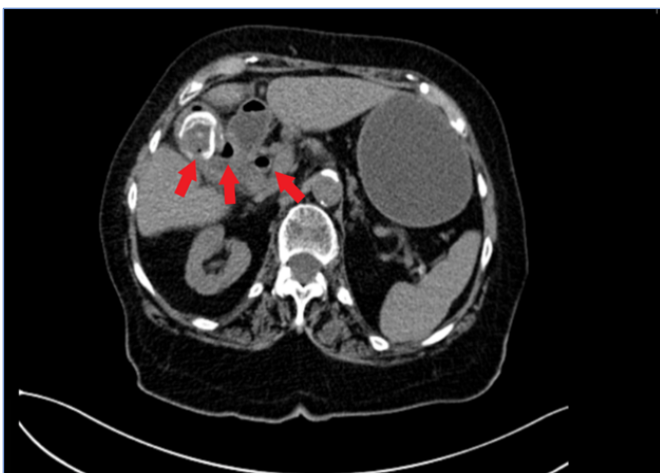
Abdominal CT without intravenous contrast (arrows pointing towards the “porcelain” gallbladder with intraluminal remnant gallstones)
